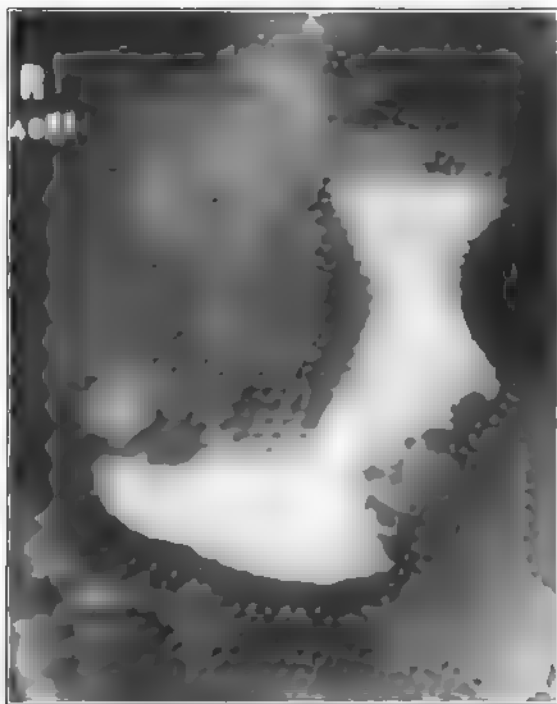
(Case No. A90,077; X-ray No. 24,021.) Female, aged fifty-six. Filling defect and irregularity especially of the pars media extending well up in cardia. No residue. Exploration: Inoperable carcinoma.
